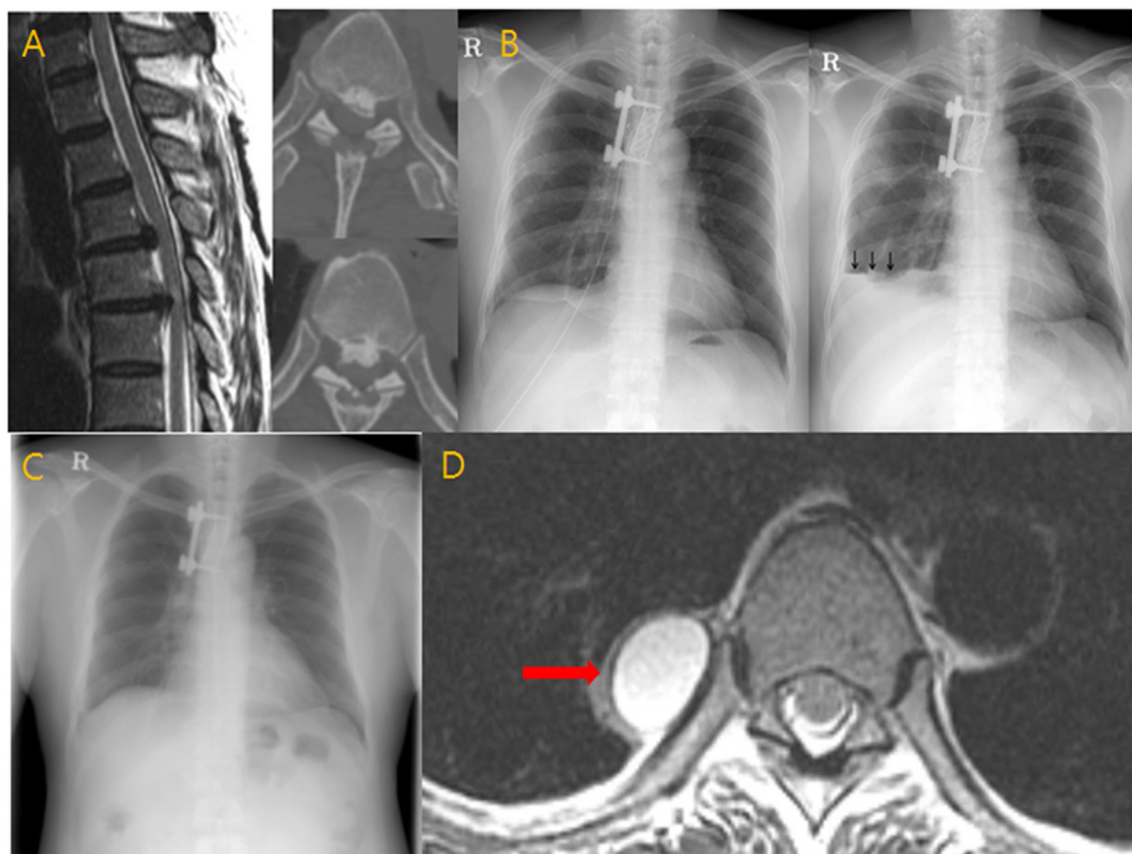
Case 1; (A): Preoperative MRI and CT which showed cord compression with signal change and OPLL (B): Chest X-ray image two weeks after surgery and immediately before removing the chest tube due to pleural effusion (left). Two days after chest tube removal. Newly formed pleural effusion is observed (arrows) (right). (C): Two weeks after re-insertion of the chest tube. (D): 6 months postoperative MRI. The pseudomeningocele was stabilized.
